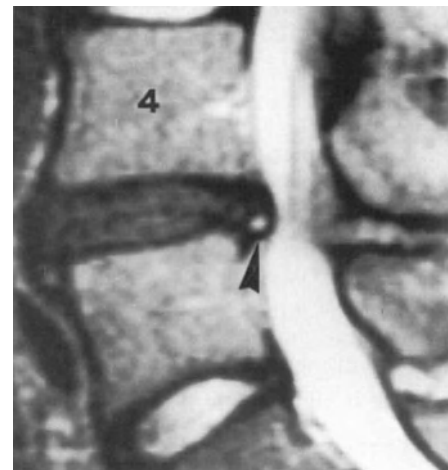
Spin-echo T2-weighted MR image. Puntiform hyperintense area in the annulus fibrosus of a disc showing a marked hyposignal due to degenerative changes.
